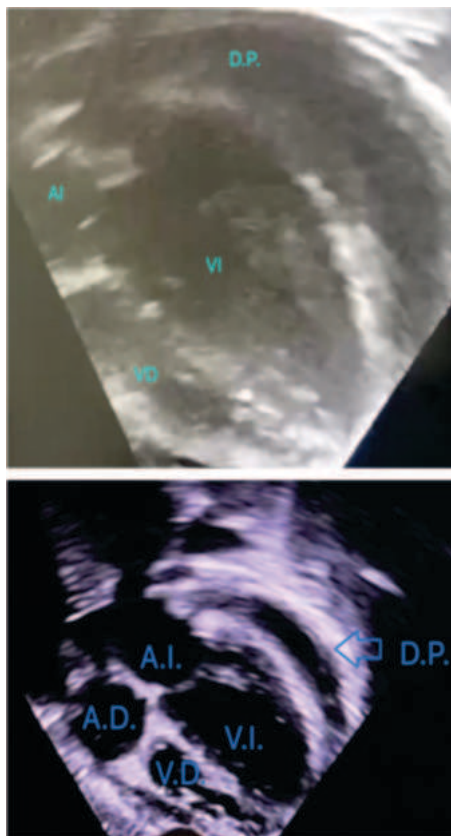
Echocardiogram demonstrating global pericardial effusion of posterior predominance. AI (Left Atrium), VI (Left Ventricle), VD (Right Ventricle), DP (Pericardial Effusion).
